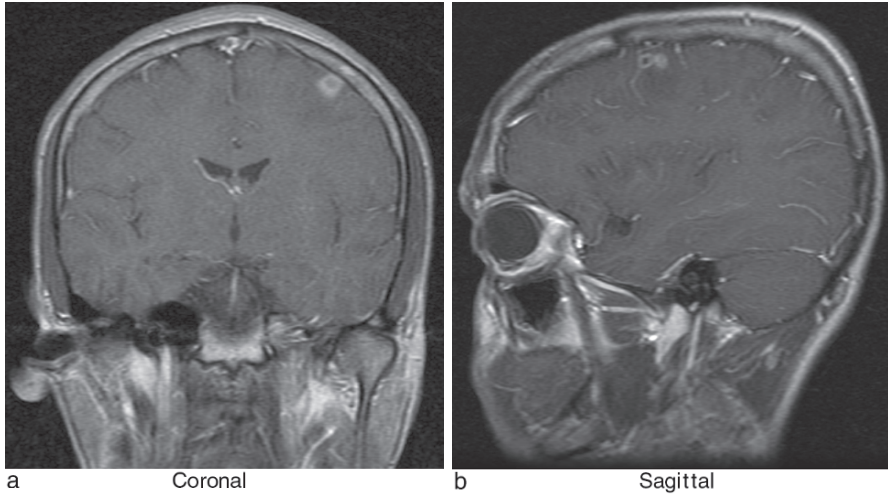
Neurocysticercosis in a 17-year-old boy who presented with afebrile seizures. a Coronal and b sagittal T1-weighted post-gadolinium MRI scans demonstrate left frontal cortical ring-enhancing lesions surrounded by mild vasogenic edema.
